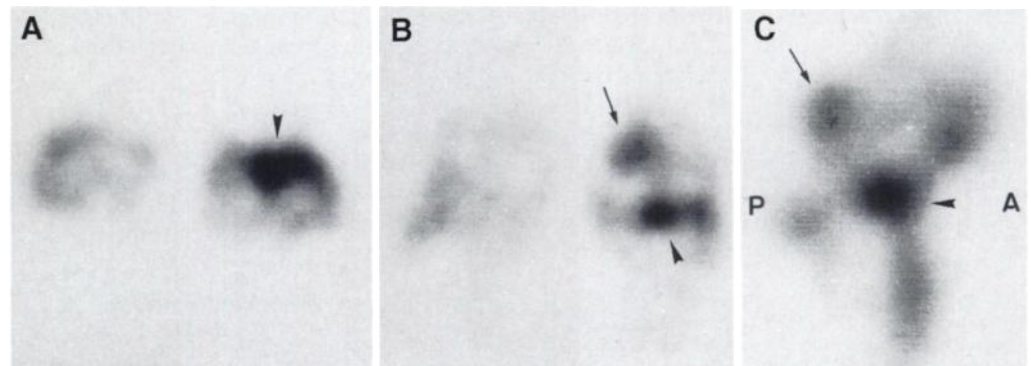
A 36-yr-old woman, 9 mo after injury to the left knee. (A) Transaxial (through the tibial plateau), (B) coronal and (C) sagittal slices show an area of increased activity in the intercondylar area of the left tibia at the lower insertion point of the ACL (arrowhead). Coronal and sagittal tomograms also show an area of activity on the lateral aspect of the medial femoral condyle at the position of the upper insertion of the posterior cruciate ligament (arrow). Both anterior and posterior cruciate ligament tears were detected on MRI.
